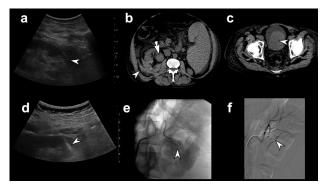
Examples of post-renal biopsy hemorrhagic complications. a–c. A 47-year-old man with estimated glomerular filtration rate (eGFR) 22.5 underwent USNFRB (arrowhead) for renal failure (a), and (b) subsequently developed a perinephric hematoma (arrowhead), with blood in the renal collecting system (arrow) and (c) bladder (arrowhead) on CT. The patient subsequently became bacteremic and developed multi-organ failure, did not respond to transfusions, and ultimately died. d–f. A 52-year-old woman with eGFR 11.7 underwent USNFRB (arrowhead) for proteinuria and renal failure (d), developed a perinephric and peritoneal hemorrhage, and subsequently underwent renal arteriography (e) demonstrating an arteriovenous fistula in the lower pole (arrowhead), successfully treated (f) with coil embolization (arrowhead).
